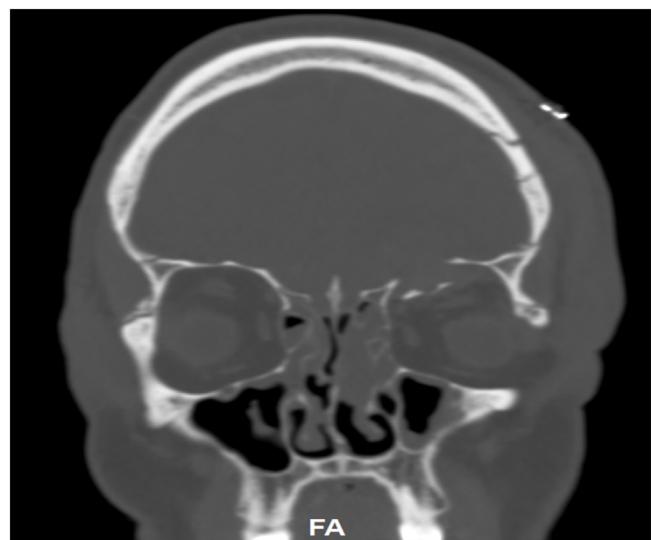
CT scan four hours after the presentation. Focal defect along the left orbital roof again noted. There is now a small (10 mm) parenchymal herniation of the left anterior inferior frontal lobe with hemorrhagic contusion through the left anterior cranial fossa defect into the superior orbit. There is opacification of the right frontal sinus; and near-complete opacification of ethmoid air cells and sphenoid sinuses.
